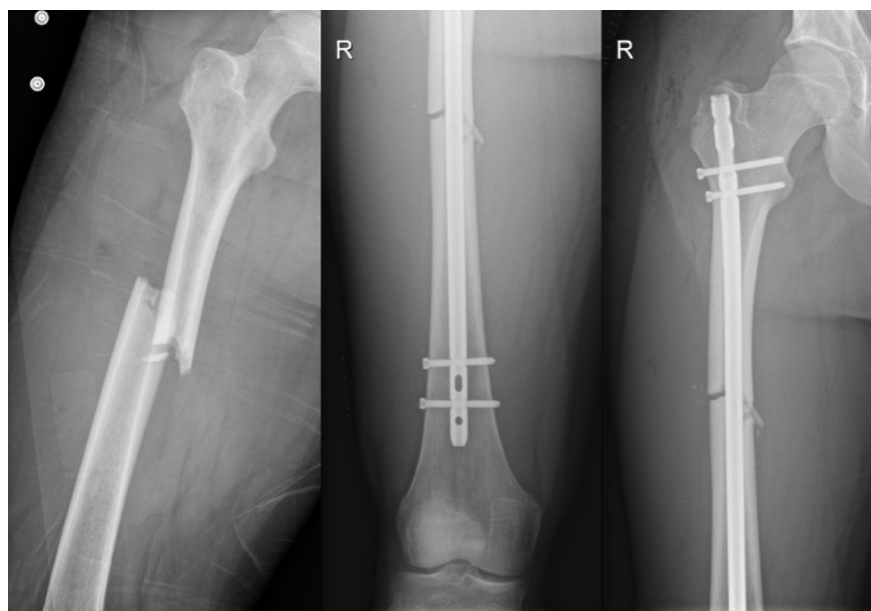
A) Midshaft fracture of the right femur. B) Postoperative radiographs showing result after endomedullary nail placement
